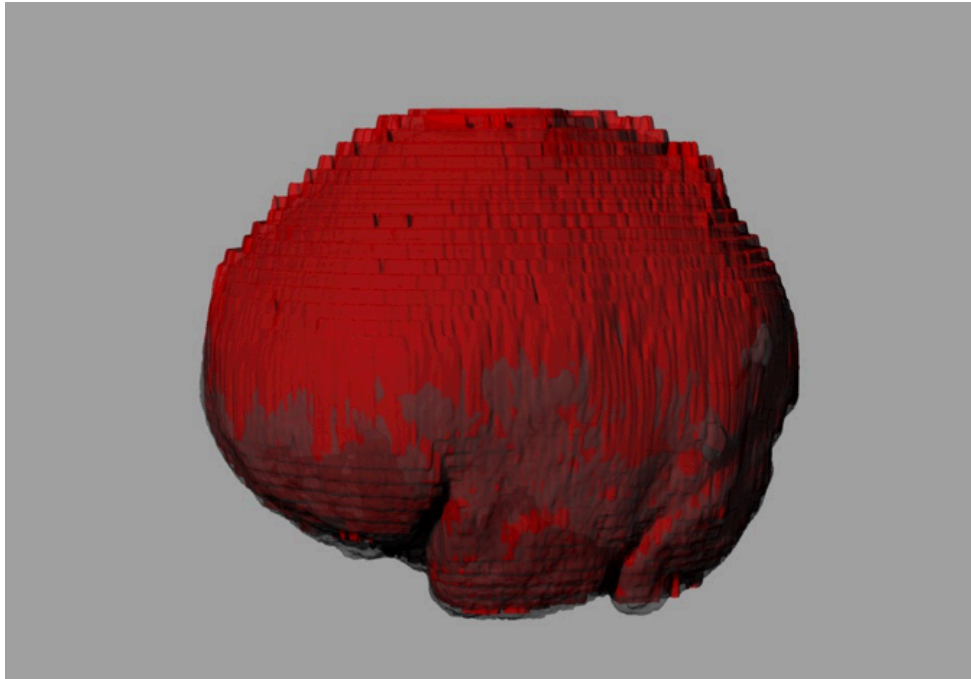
3D reconstruction of a CT scan which has been down sampled to include half the original number of slices.
